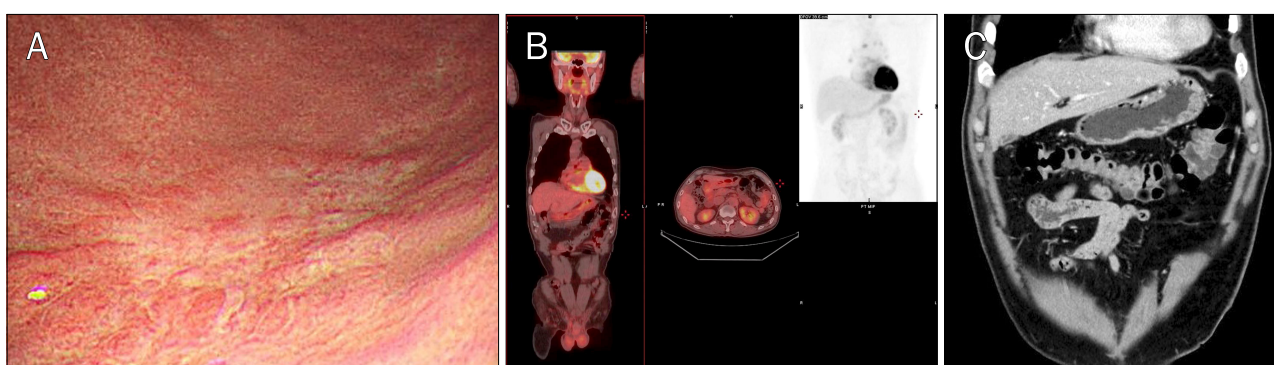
This case shows no fluorine-18 fluorodeoxyglucose (F-18 FDG) uptake in a discolorated-scar type of gastric mucosa-associated lymphoid tissue lymphoma. (A) A 53-year-old male patient had a discolorated-scar lesion on the greater curvature in lower body of the stomach. (B) F-18 FDG PET revealed no significant F-18 FDG uptake in the stomach. (C) Abdomen CT shows no wall thickening at the gastric body.
